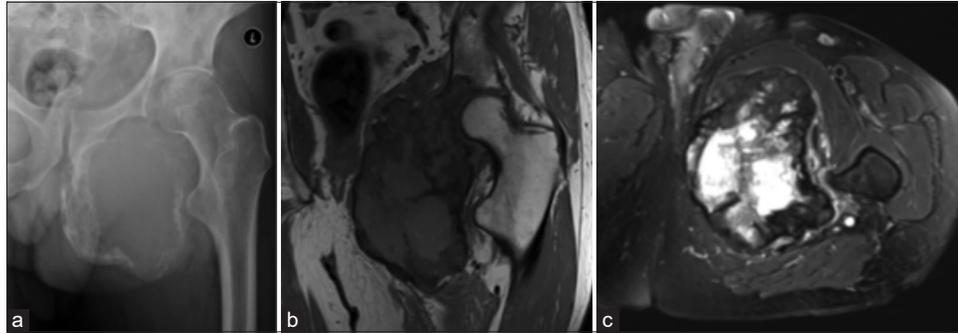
Giant cell tumor. Radiograph (a), coronal T1 (b), and axial short-tau inversion recovery (c) demonstrating large destructive lesion of the left ischium and acetabulum.
